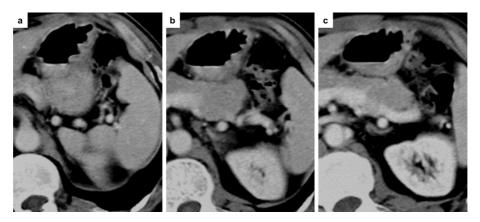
Computed tomography (CT) before distal gastrectomy against early-stage gastric cancer three years earlier showing no cystic lesion.
